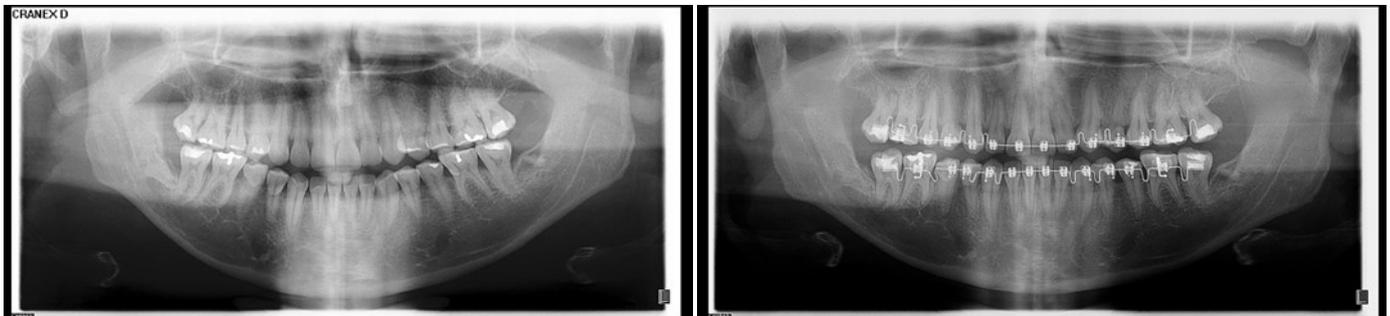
Tele radiography pre-treatment (left) and pos-treatment (right).
